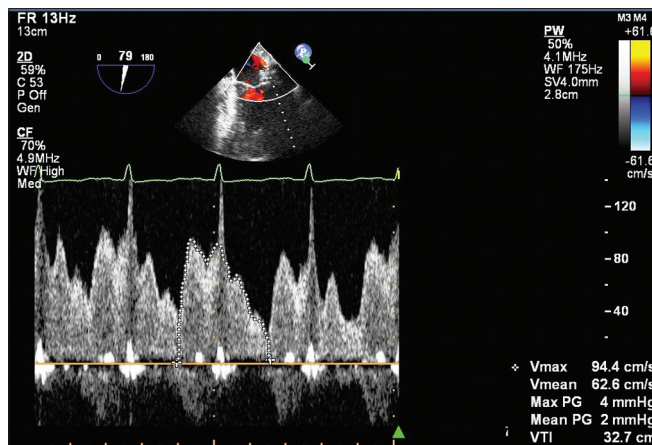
Postoperative transesophageal echocardiography-mid esophageal left upper pulmonary vein pulsed wave Doppler showing peak velocity of 0.95 m/s
